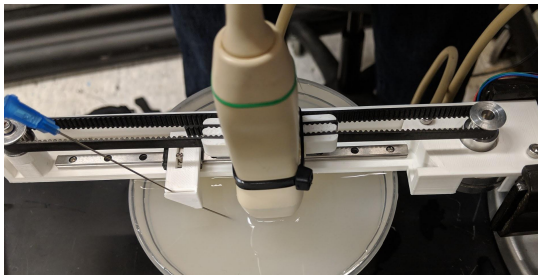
Test bed for moving a ultrasound phased array
